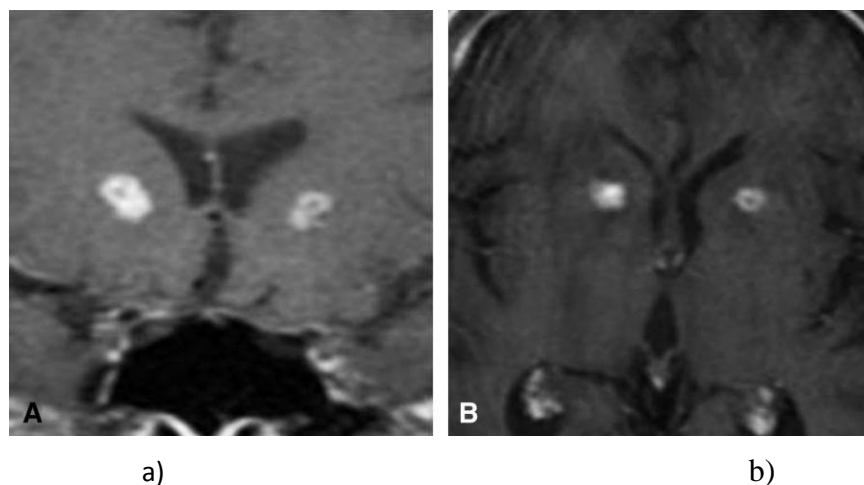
MR images belong to a patient after radiosurgery, a) Coronal and b) Axial
